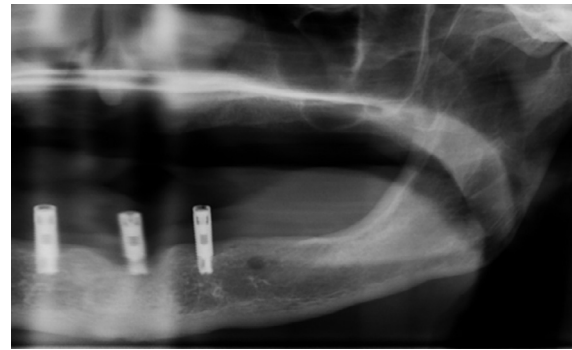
Panoramic radiograph confirming that the lesion is limited to the soft tissue without intraosseous extension.
